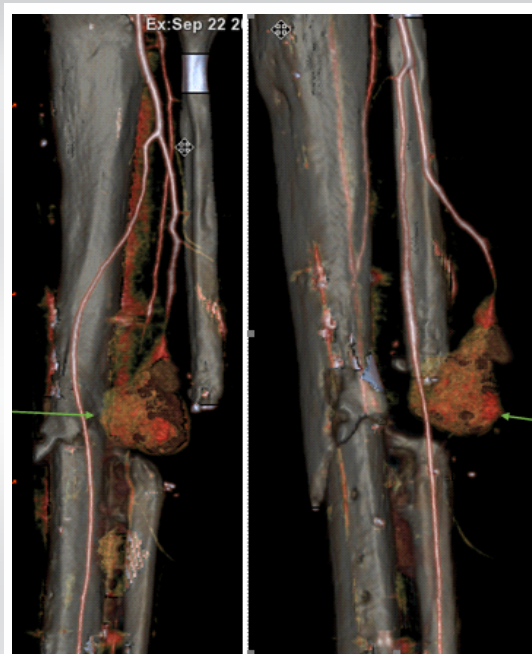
Axial sections of computed tomography angiography of the right leg showing pseudoaneurysm arising from peroneal artery (marked by arrow).
